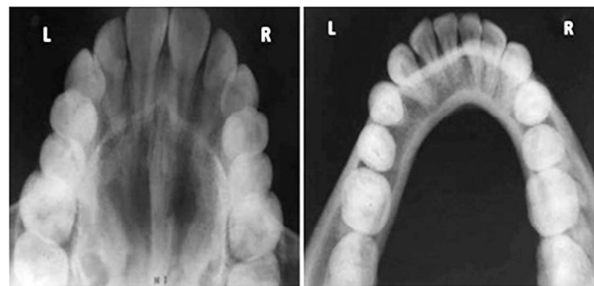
Occlusal Radiograph representing right & left side.
